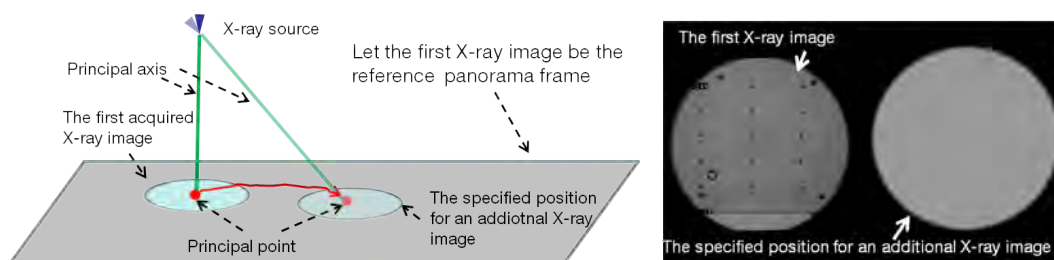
The reference panorama frame is defined by the first X-ray image. Any subsequent X-ray images can be registered to the reference frame in order to build the final panorama. The right image shows that the area of the X-ray image projected in the panorama is visualized as a grey circle in our implementation.
